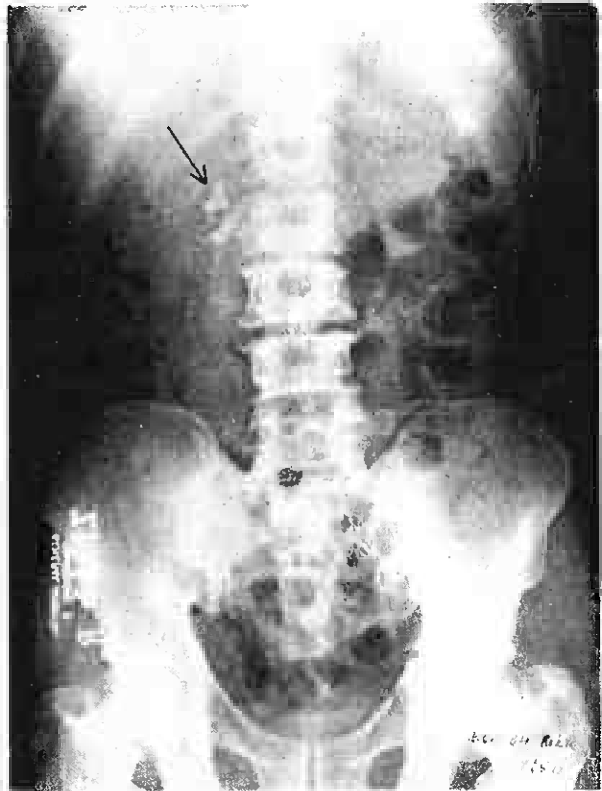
Plain X-ray of another case of chronic pancreatitis showing extensive calcification of the head of the pancreas (arrow).
